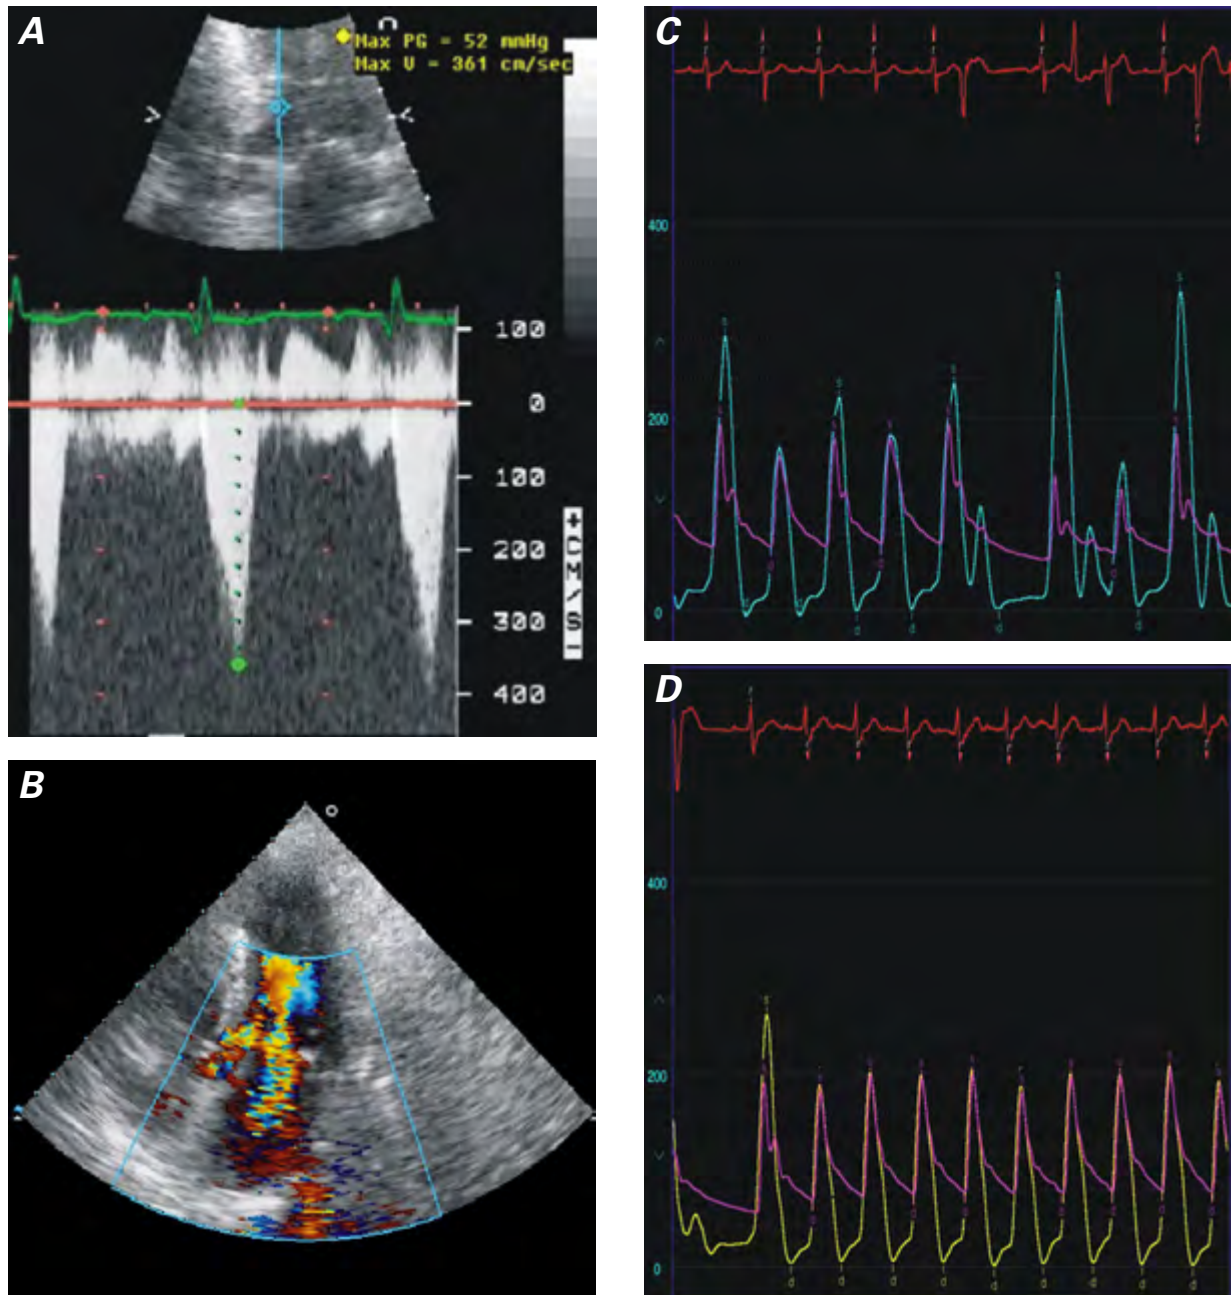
Transthoracic echocardiogram reveals A) a decrease in the resting left ventricular outflow tract gradient to 52 mmHg after normal saline hydration and low-dose β -blocker therapy, and B) persistent substantial mitral regurgitation after hydration (color-flow Doppler mode). During left-sided heart catheterization, continuous-wave Doppler pressure recordings show C) a provokable peak-to-peak gradient of 159 mmHg before alcohol septal ablation and D) a decrease to 9 mmHg after ethanol was injected into the first septal branch.
